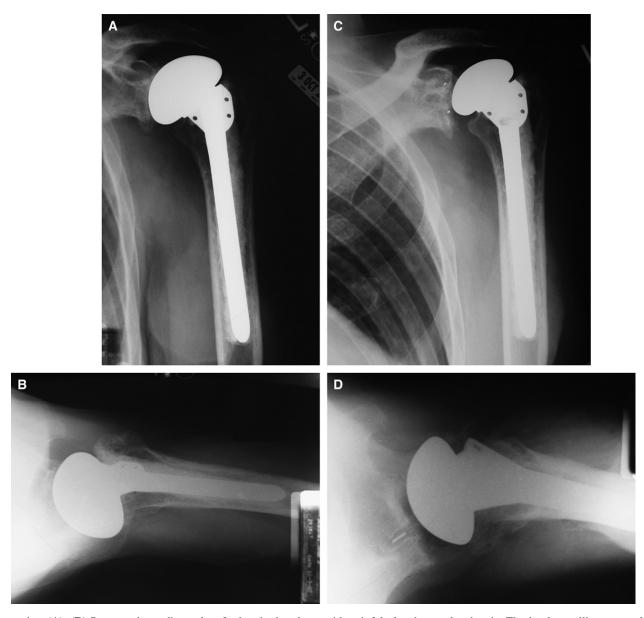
(A), (B) Preoperative radiographs of a hemiarthroplasty with painful glenohumeral arthrosis. The implant utilizes a standard male Morse taper. (C), (D) Postoperative radiographs after treatment with modular head revision, implantation of pegged glenoid component, and retention of original stem component.
